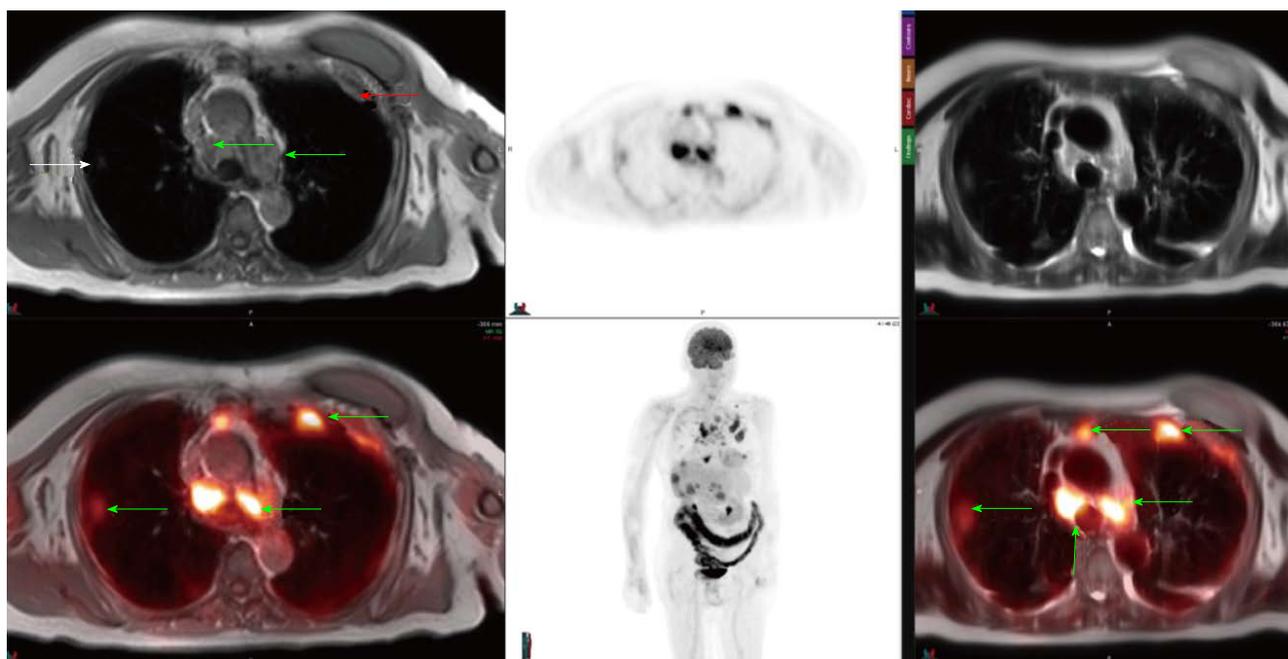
A 65-year-old patient with osteosarcoma underwent positron emission tomography-magnetic resonance imaging for annual follow-up. There were multiple nodular T1 isointense and T2 hyperintense foci (relative to skeletal muscle) noted which demonstrated FDG uptake, compatible with neoplastic activity. Biopsy were positive for metastatic osteosarcoma. FDG: 18F-fluorodeoxyglucose.
